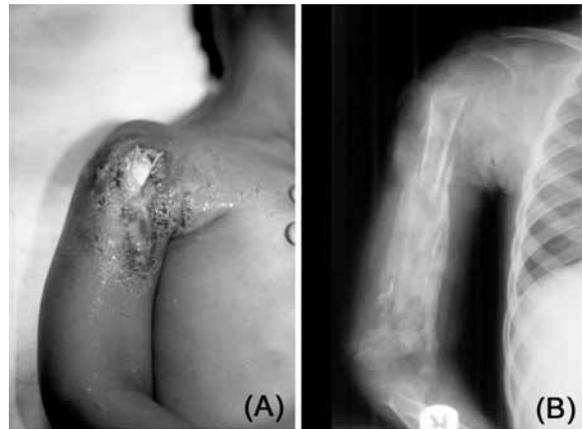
Stage 3 HO of the humerus in a 5-year-old child with (A) spontaneous extruding sequestrum, as seen on (B) a “road map” x-ray.
